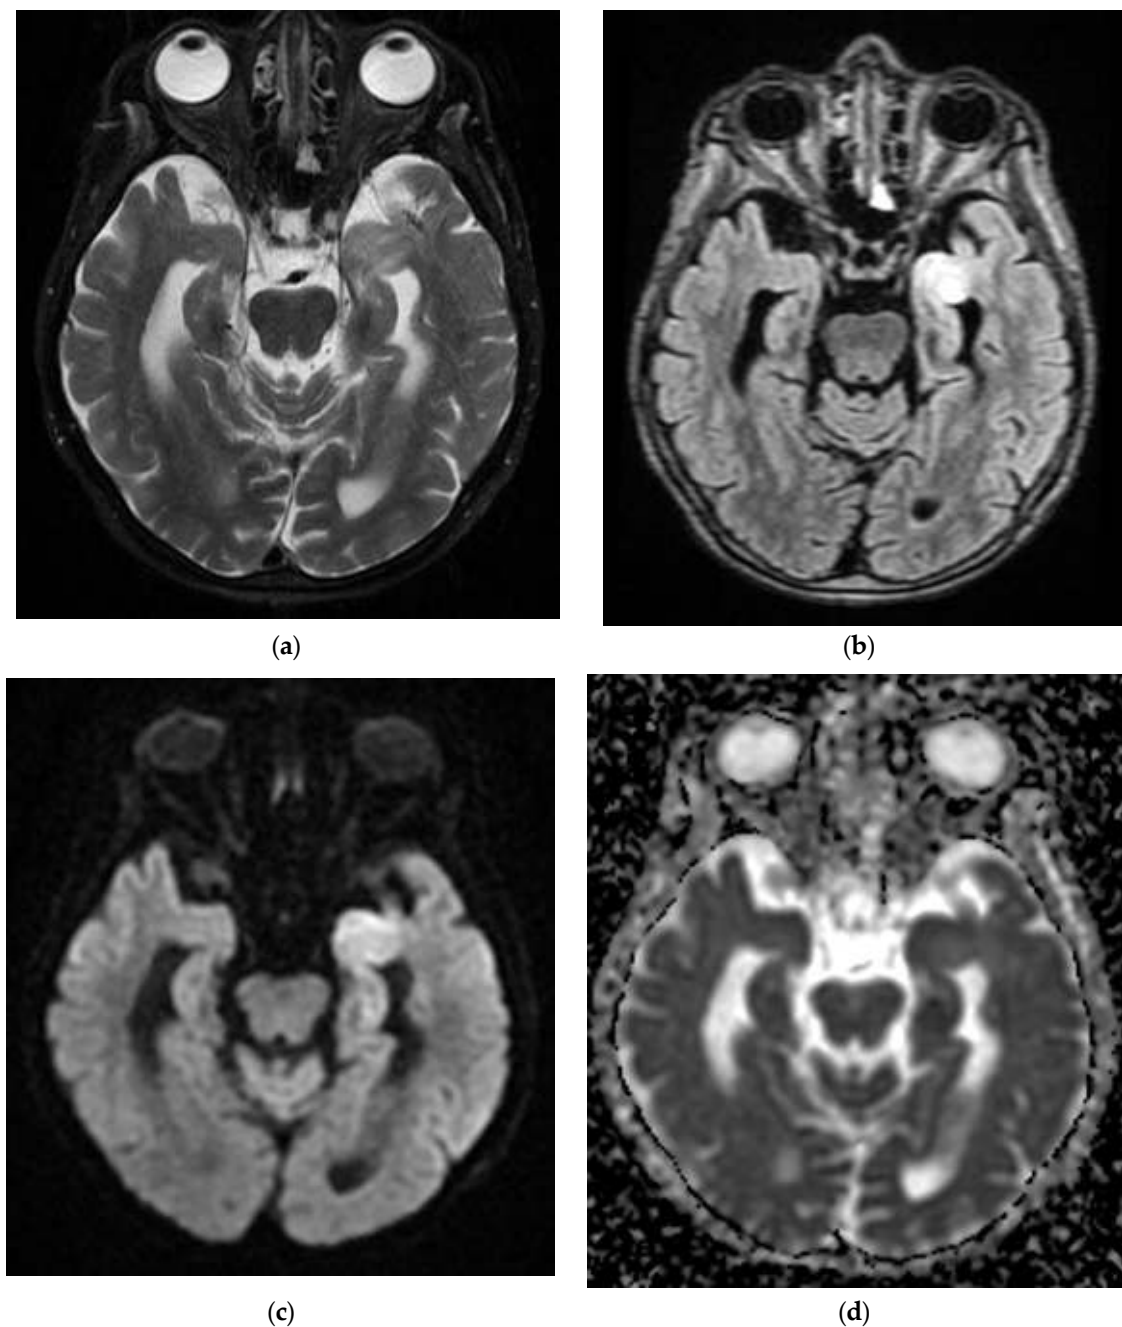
Cerebral MRI examination of the Case 5 patient highlights inaccurately delimited area of intense T2 and FLAIR signal (a,b), slightly restrictive in diffusion (c,d), situated in the cortical and subcortical area of the left tonsil. These images are conclusive for subacute tardive infarction on the territory of the anterior choroidal artery.
